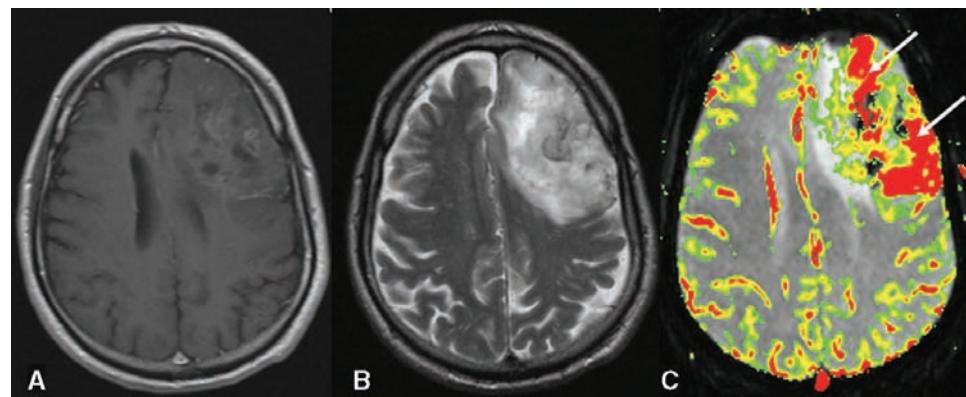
A 63-year-old male (patient no. 6) with a pathology proven anaplastic oligodendrogloma with high-perfusion rCBV of 8.08 and 1p19q allelic deletions. (A) Contrast-enhanced axial T1-weighted image (600/14) demonstrates a mass in the left frontal region with patchy contrast enhancement. (B) Axial T2-weighted image (3400/119) demonstrating mass effect with midline shift and some mass effect on the left lateral ventricle. (C) Gradient-echo (TR/TE 1,000/54) axial DSC MRI perfusion image, with rCBV color overlay map, shows a lesion with very high perfusion, rCBV of 8.08 (arrows). Key for color map: No color depicts baseline white matter perfusion; green depicts threshold gray matter perfusion; yellow depicts increased perfusion; red depicts maximal perfusion (the cortical vessels also demonstrate normal perfusion). Abbreviations: rCBV, relative cerebral blood volume; TR, repetition time; TE, echo time; DSC MRI, dynamic susceptibility contrast MRI.
